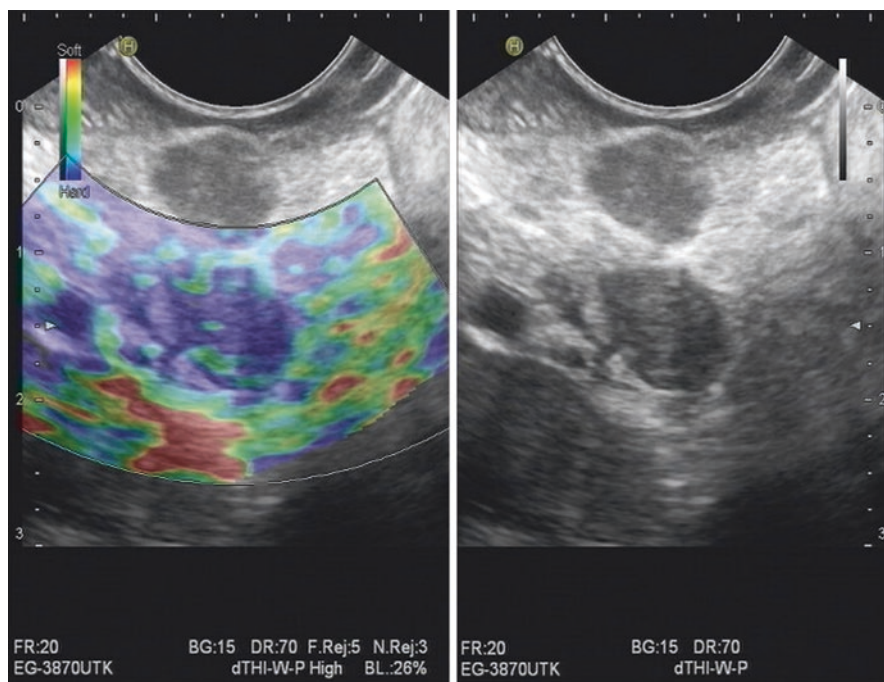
Endoscopic ultrasonography imaging of round, sharply demarcated and hypoechoic malignant lymph nodes, also evaluated by elastography
